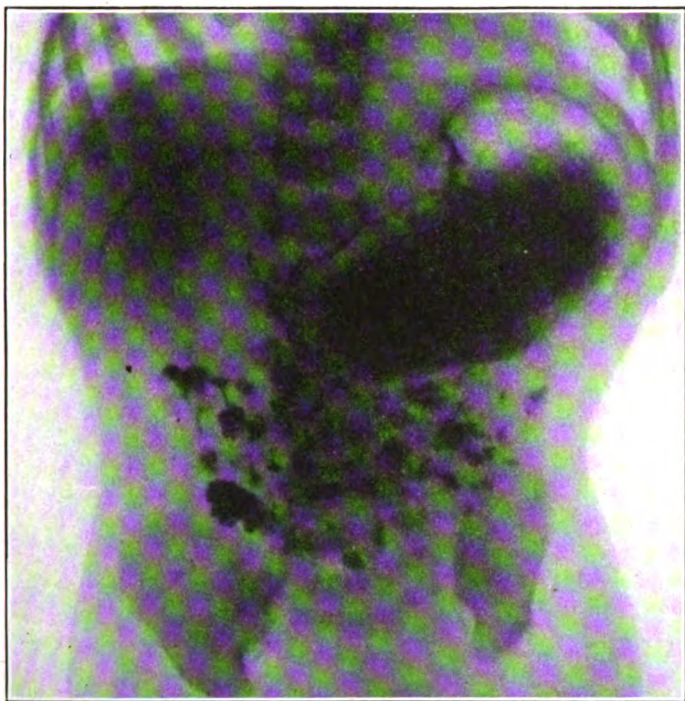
Roentgenogram of stomach immediately after feeding showing oblique position and early passage of food through the pylorus.
